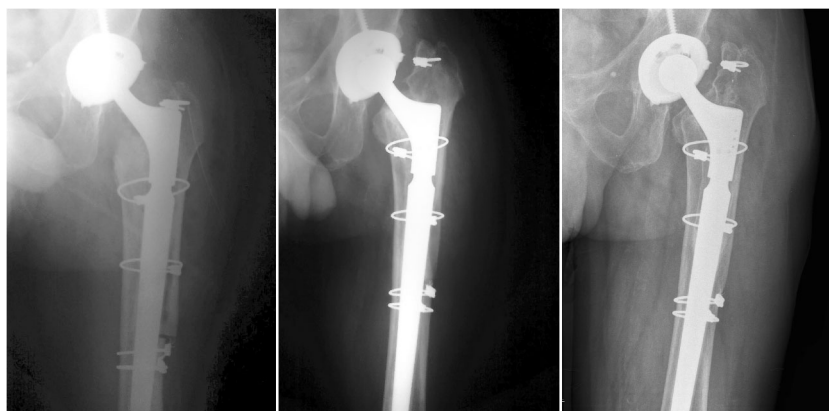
Radiographic signs of consolidation of the periprosthetic femoral fractures (PFF) at three months after surgery
